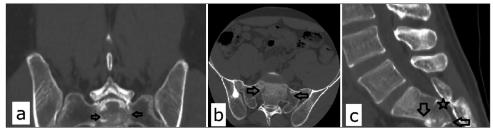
Appearance of the sacral fracture on a computed tomography scan: (a) Coronal plane. Black arrows point to the vertical parts of the fracture on each side. (b) Axial plane. Black arrows point to the oblique parts of the fracture on each side. (c) Sagittal plane. Black arrows point to the anterior and posterior end of the transverse part of the fracture. A black star indicates the level of the most significant central canal stenosis.
